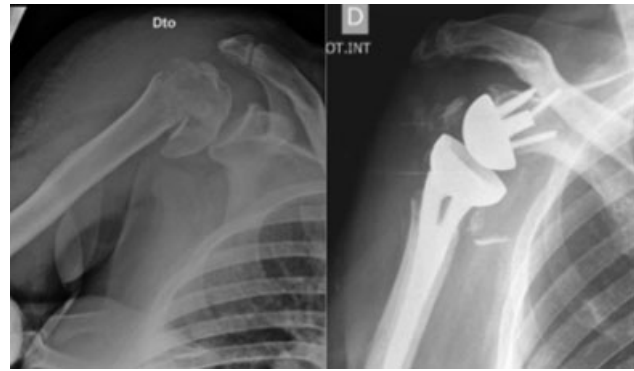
Radiograph showing non-healed tuberosities.
